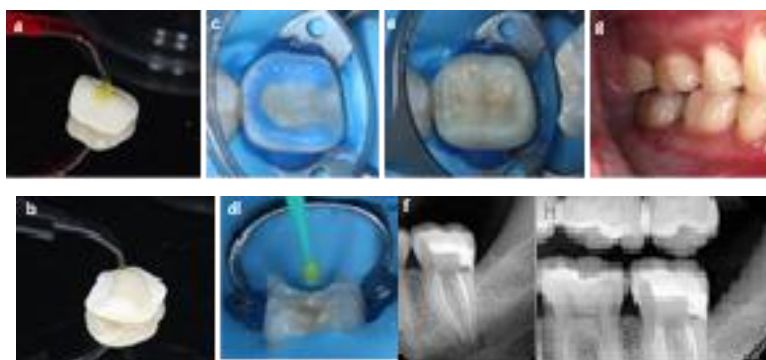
a) Application of HF porcelain etching b) Silane c) Selective etching on enamel d) Bonding e) Onlay cementation f) Periapical radiography evaluation g) Articulation and occlusion check h) Bitewing radiography evaluation.
